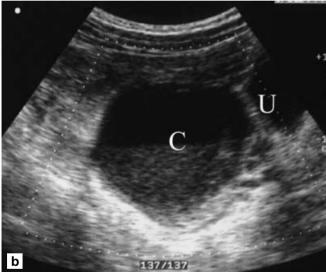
Ultrasound of hemorrhagic cyst. a Transvaginal US demonstrates a solid-appearing mass (C), but with some posterior acoustic enhancement (asterisk). b Transabdominal US obtained 8 days later. The structural pattern is changed, and a fluid–fluid level is well visualized. C cyst; U urinary bladder
